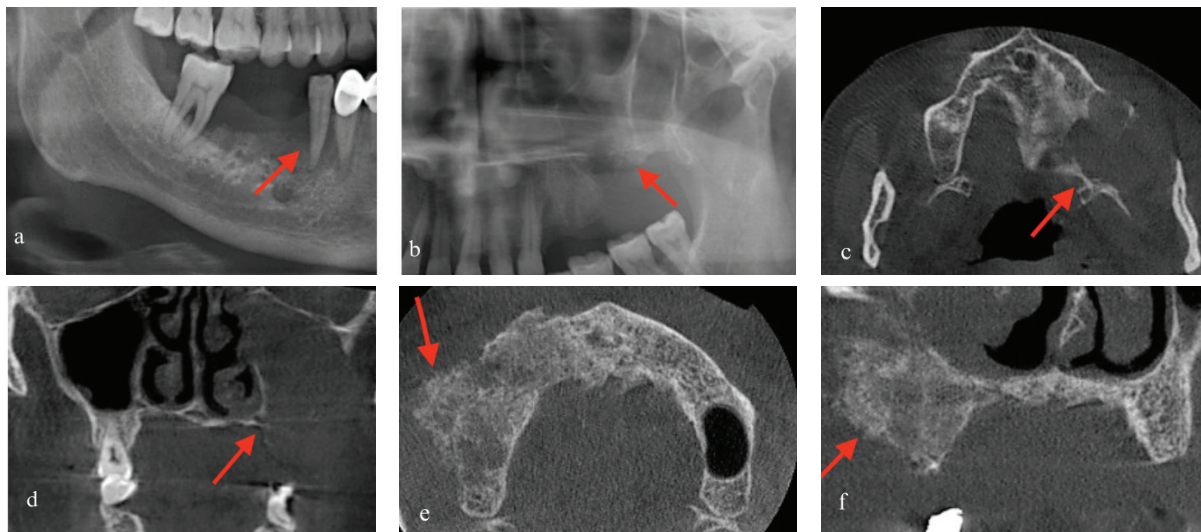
Panoramic and CBCT images in patients diagnosed with SCC and osteosarcoma.
